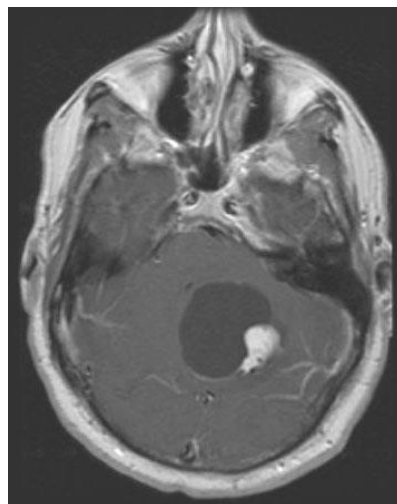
ShowsThe Cerebellar hemangioblastoma with hydrocephalus. (MRI image).
